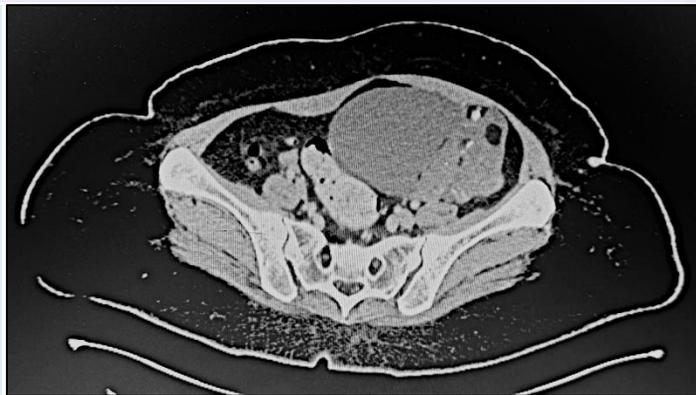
A slice of CT TAP showing left ovarian teratoma
